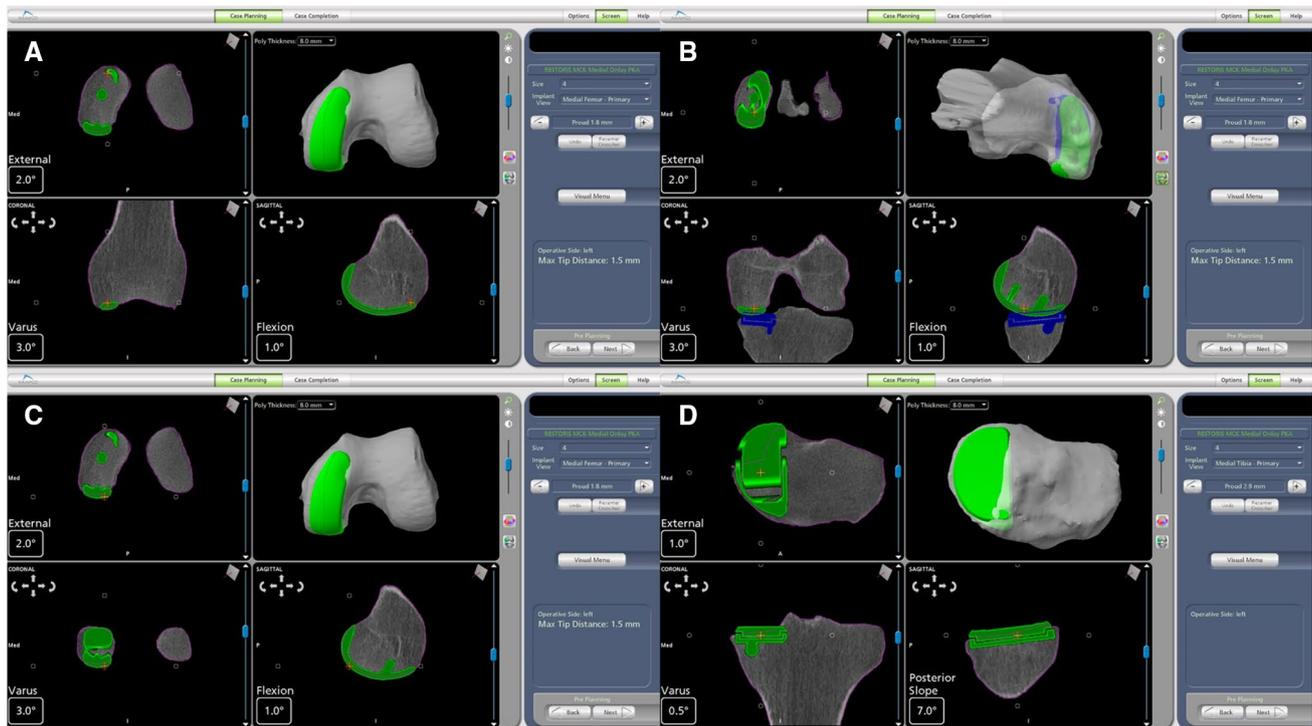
Computed tomography-based preoperative planning for robotic-arm-assisted medial unicompartmental knee arthroplasty (screen capture from software) in a 70-year-old woman; planned positioning of the femoral (a–c), and tibial (d) component. The desired
